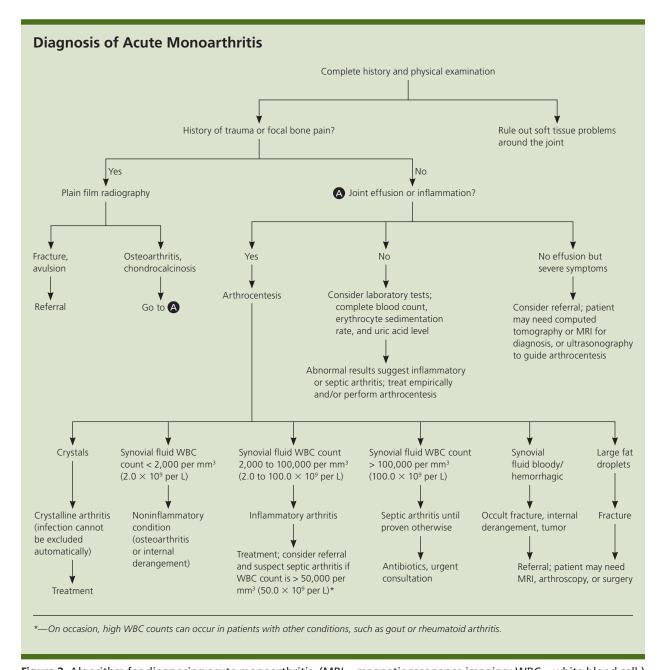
Algorithm for diagnosing acute monoarthritis. (MRI = magnetic resonance imaging; WBC = white blood cell.)
